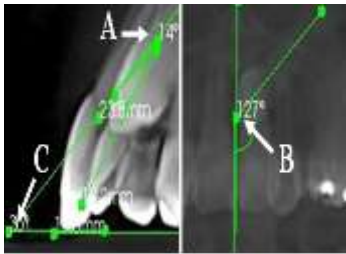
Angles measured in CBCT
